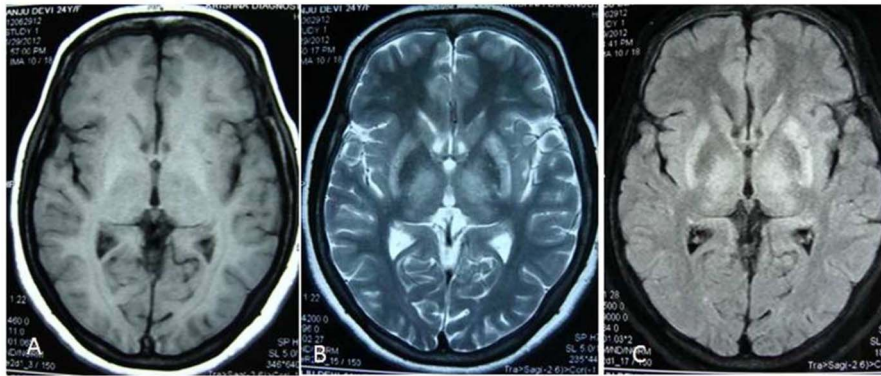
Axial MRI brain (A) T1-weighted image shows isointense signal in both caudate nuclei suggestive atrophy and necrosis of caudate, (B) and (C) T2-weighted and fluid attenuated inversion recovery images, respectively, show hyperintense signal bilateral caudate, putamen and thalamus typical of Wilson disease.
